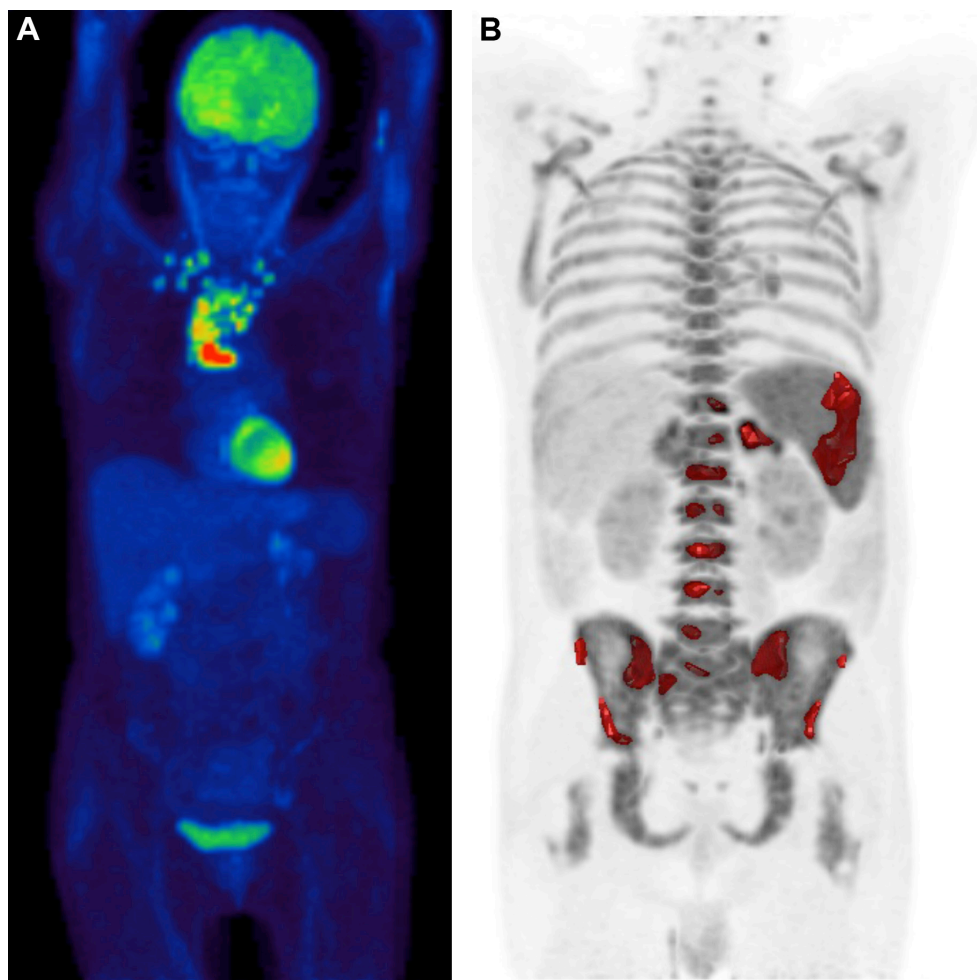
(A) Maximum Intensity Projection (MIP) view displayed with a colour scale to identify the highest SUVmax. By displaying the MIP using a colour scale rather than the standard gray scale, it is easier to identify the area of most intense uptake in order to calculate the Δ SUVmax. (B) Image of metabolic tumour volume in a patient with diffuse large B-cell lymphoma. Areas of uptake as defined by SUVmax above a predefined threshold are highlighted in red and superimposed over a MIP view. Acknowledgments to Helena McMeekin, nuclear medicine physicist, Royal Free London.
